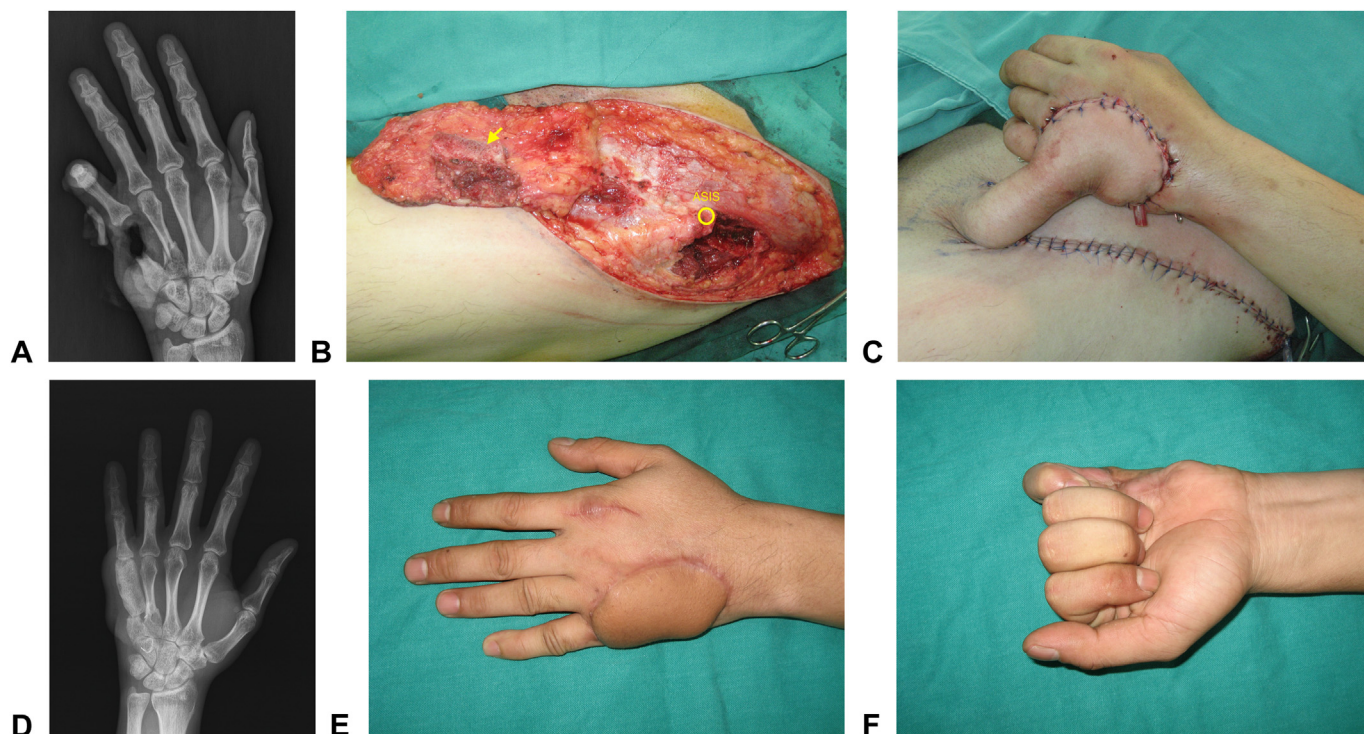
A Left hand crush injury with fifth metacarpal defect and fourth metacarpal base fracture. B An iliac osteocutaneous flap was harvested, including the iliac crest bone with the periosteum still attached, as marked by an arrow. The anterior superior iliac spine (ASIS) was marked with a yellow circle. C Immediate postoperative picture. D–F X-ray and MCP joint range of motion at the 7-month follow-up.
